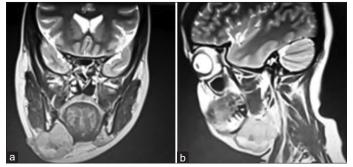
Pre-operative magnetic resonance imaging of the patient
